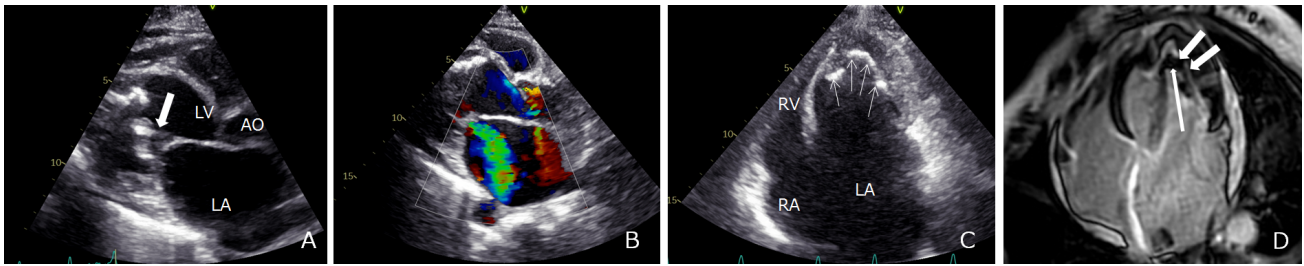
LV-EMF patient. (A,B) LV long axis view shows mitral valve chordae tendineae thickening and echo enhancement (arrow), papillary muscle fusion to TFE and thrombus, valves being pulled down during systole and mild MR. (C) Apical 4-chamber view during systole shows significant LA enlargement, LV apical occlusion, and thrombus calcification (arrows). (D) CMR late gadolinium enhancement TFE shows typical “V sign” (short arrows). The upper black area in TFE represents the thrombus (long arrow). LV, left ventricle; LA, left atrium; MR, mitral regurgitation; AO, aorta.
